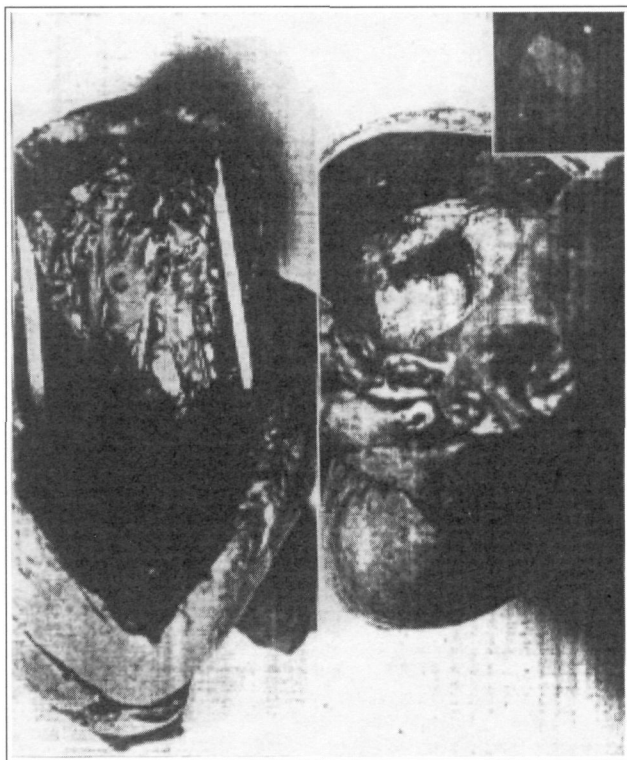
(case 5).—Auricular and ventricular views of the mitral orifice; the roentgen-ray film (inset) shows some calcium deposition. The sharp border of the valve edge in the ventricular view where the incision was made at operation may be noted.
